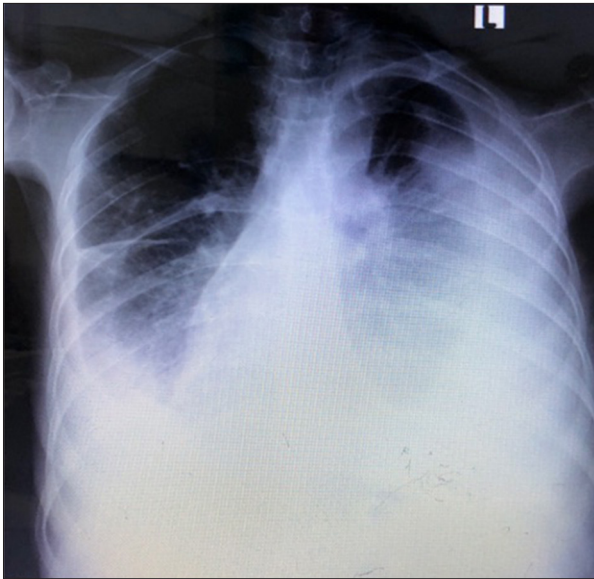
Chest X-ray at the one-year follow-up showed bilateral pleural effusion.
